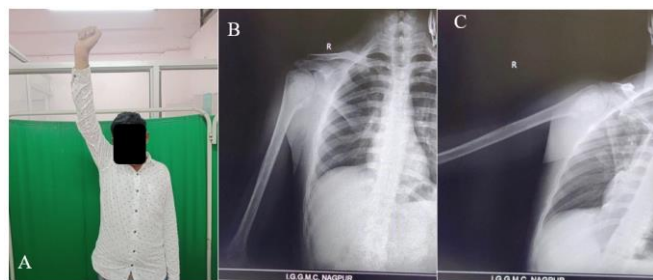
(A) Full ROM, (B) & (C) X-rays at 3 months followup.
